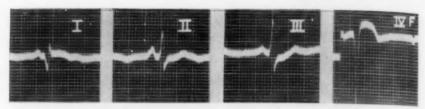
Ventricular aneurysm diagnosed by roentgenogram and by physical examination. Tracing shows elevated ST and prominent Q in I and IVF during a period when there was no evidence of active myocardial infarction. Fluoroscopy confirmed an anteroapical ventricular aneurysm.
